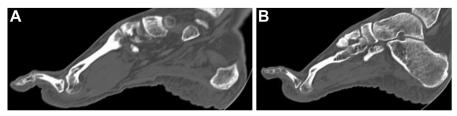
(*A*) Sagittal computed tomography, M2 with a 90° flexion metaphyseal malunion: (*B*) Sagittal computed tomography, M3 with a flexion diaphyseal malunion.
